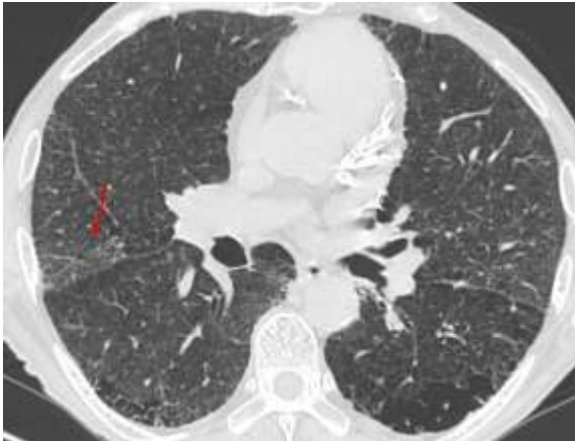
RB-fibrosis. Axial CT one cm inferior to Fig. 2 shows reticular opacities along with the RB findings, suggesting RB with fibrosis or RB-fibrosis, a type of SRIF (see below).
